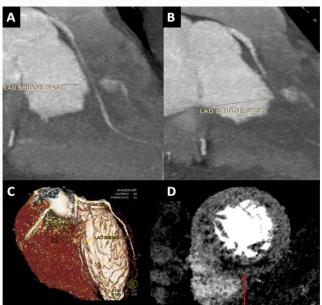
CCTA. A) CCTA image showing the myocardial bridge in the LAD and B) LAD obliteration in systole. C) 3D volume rendered CCTA image showing the myocardial bridge in diastole. D) Minimum intensity projection CCTA image showing the myocardial infarction (red arrow). CCTA: Coronary Computed Tomography Angiography; LAD: Left Anterior Descending Artery
